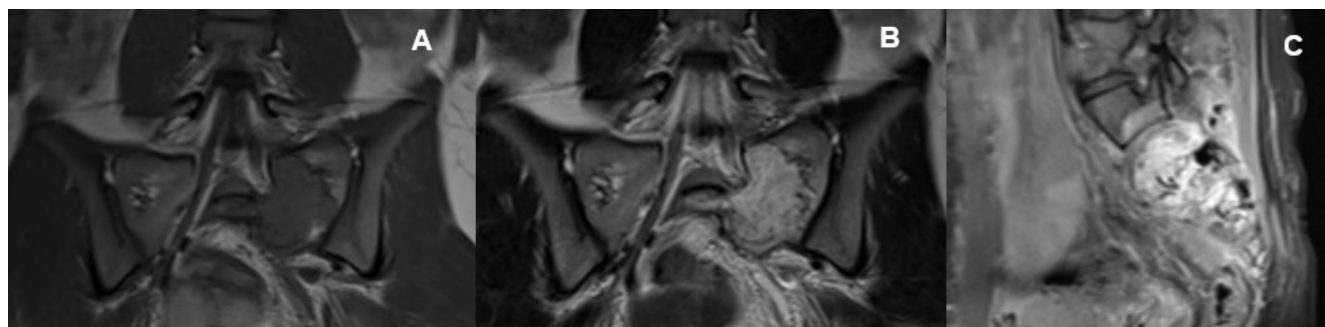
Case 1. Sacral capillary hemangioma. Preoperative MRI. (A) Coronal section, T1WI showing a non-enhanced isointense mass within the left sacrum. (B) Coronal section, T2WI showing hyperintensity of the lesion. (C) Sagittal section, T1WI C+. Note the avid enhancement of the lesion.
